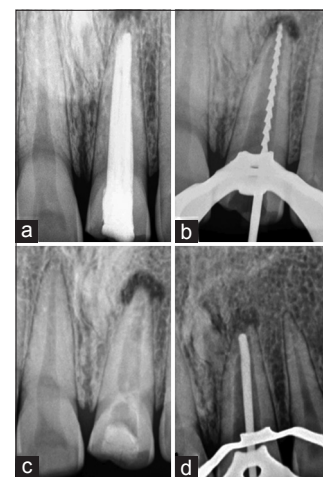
(a) Preoperative radiograph showing under filled tooth number 21. (b) Working length radiograph after the removal of root canal filling. (c) Placement of intra-canal medicament. (d) Master cone (number 80, 0.02% butt end) selection radiograph
